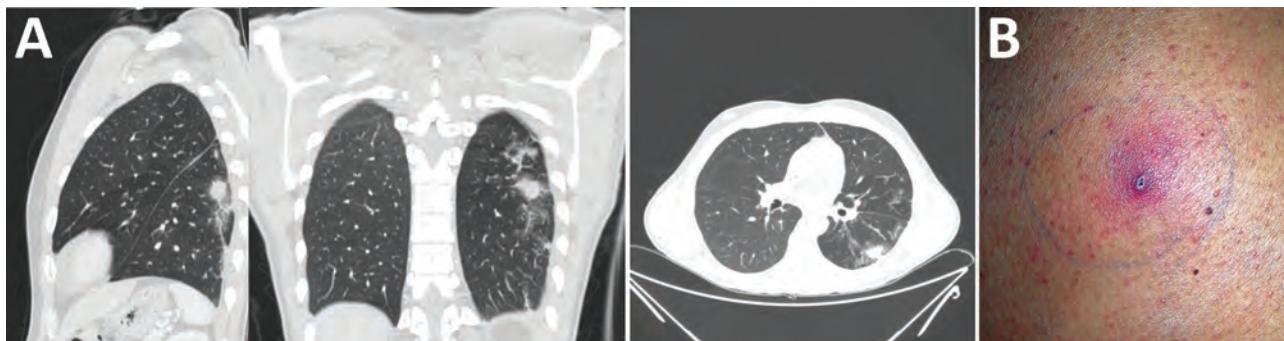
Pulmonary nodule and skin lesion in patient with invasive fungal disease caused by *Inonotus* spp., Madrid, Spain. A) Computed tomography of the lungs shows pulmonary nodule with halo sign in the left superior lobe, with peripheral distribution. B) Skin lesion at biopsy site 4 weeks after biopsy.
